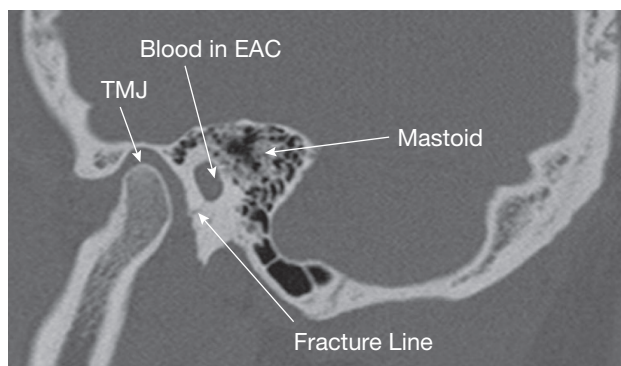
The sagittal CT of our patient's temporal bone shows the fracture line extending into the anterior ear canal and involving the temporomandibular joint (TMJ). "EAC" stands for "external auditory canal."
